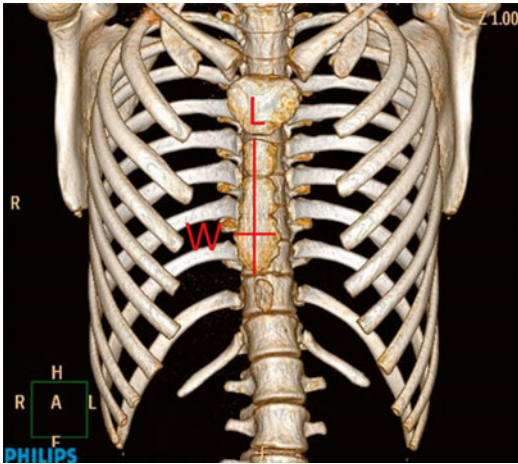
Lines *W* (widest length of the ossified sternal body) and *L* (longest length of the ossified sternal body), are used for the study of the WL index in coronal CT Scans. The Width Length Index is calculated by the division of *W* by *L*
